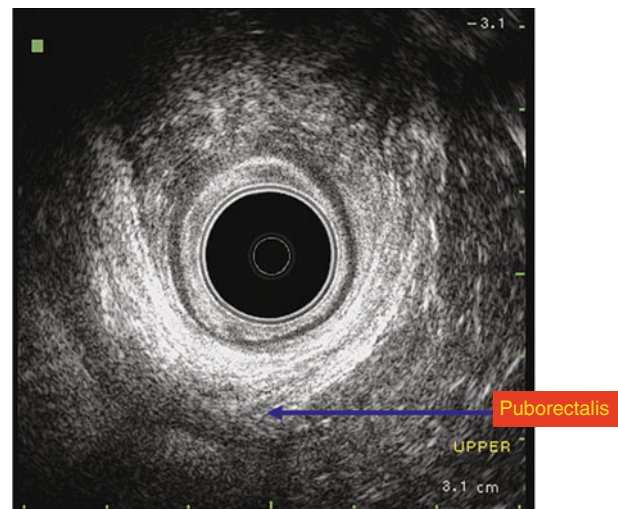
Upper anal canal. Endorectal ultrasound image of a normal anal canal. Note the “sling-like” appearance of the puborectalis
